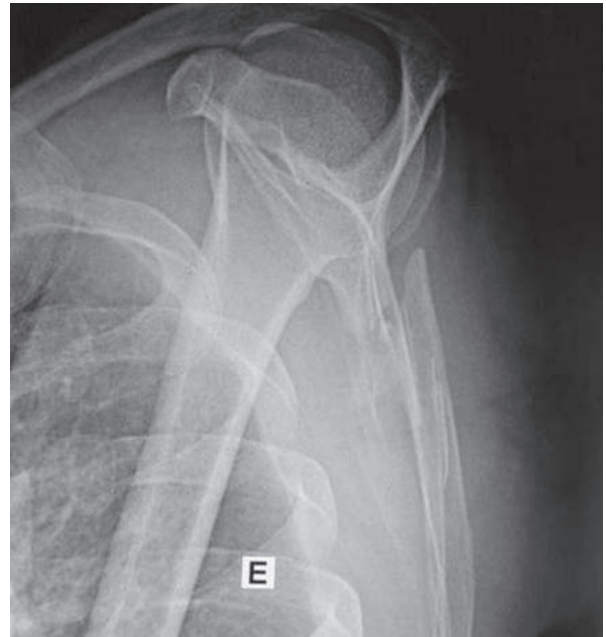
Right shoulder radiographic lateral view – scapular extra-articular fracture.
